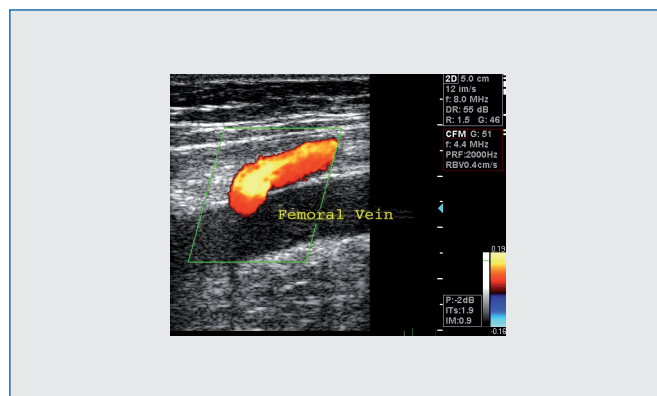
Identification with color duplex ultrasound of an incompetent perforator vein in the femoral canal.
